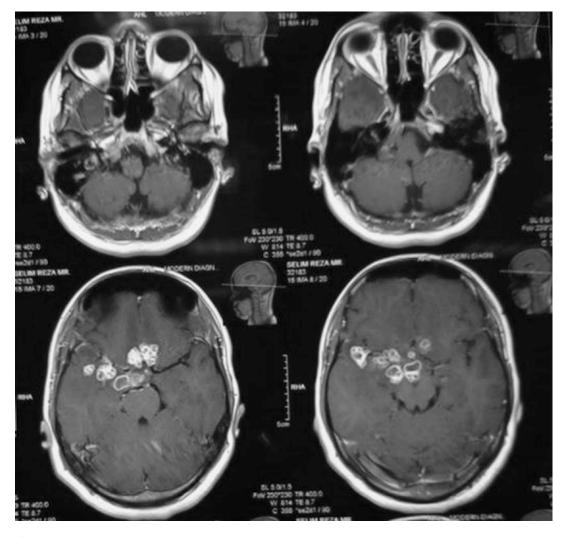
Axial T1-weighted contrast-enhanced MRIs demonstrating multiple tuberculomas in the basal parts of both the cerebral hemispheres and brainstem (Courtesy of FH Chowdhury)
